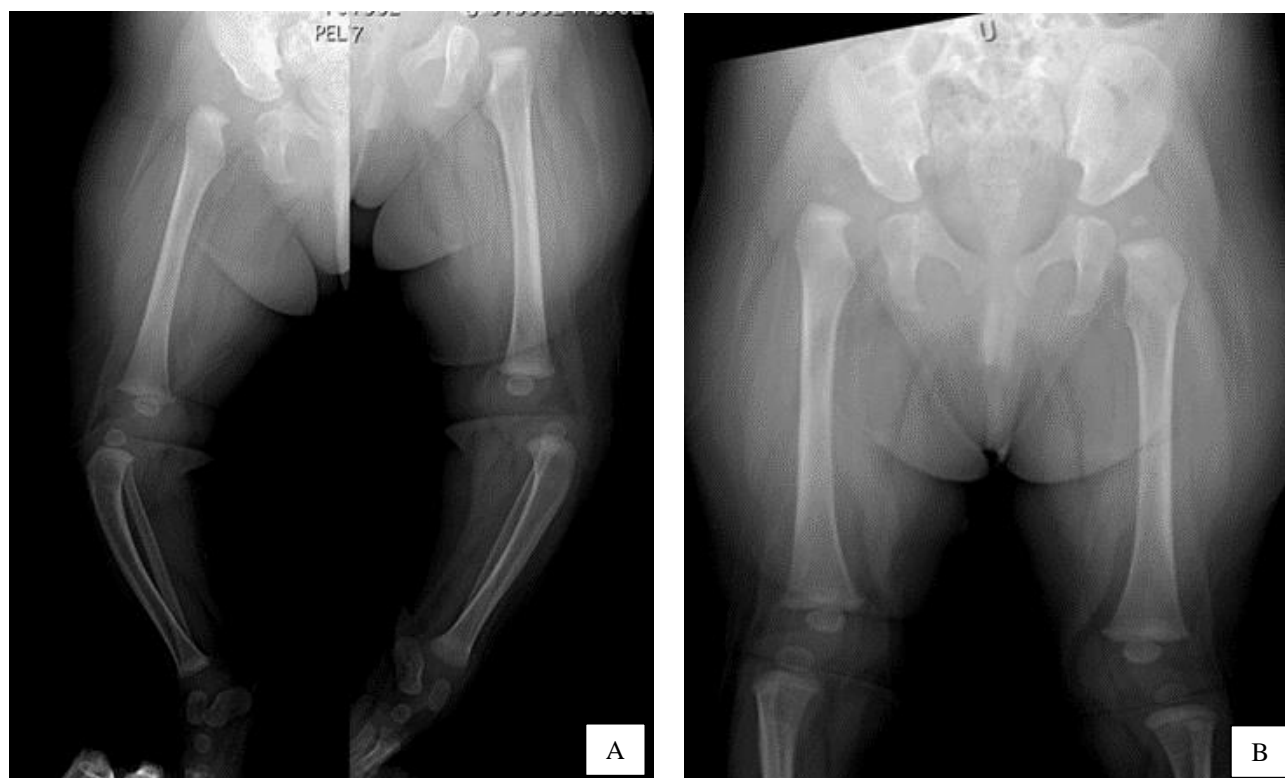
A - Case one, X-ray image of lower limb in lateral view, the bowing of both tibiae in sagittal plane compensate the knee dislocation. B - Case one, X-ray exam of the right dislocated hip.
